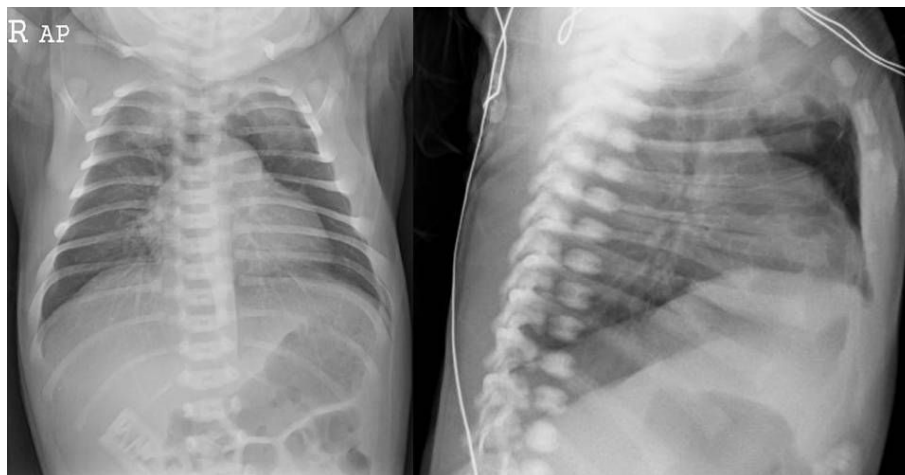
Chest anteroposterior and lateral view x-ray scan on admission demonstrate multiple bullous changes in the anterior mid-chest and an enlarged thymus.
